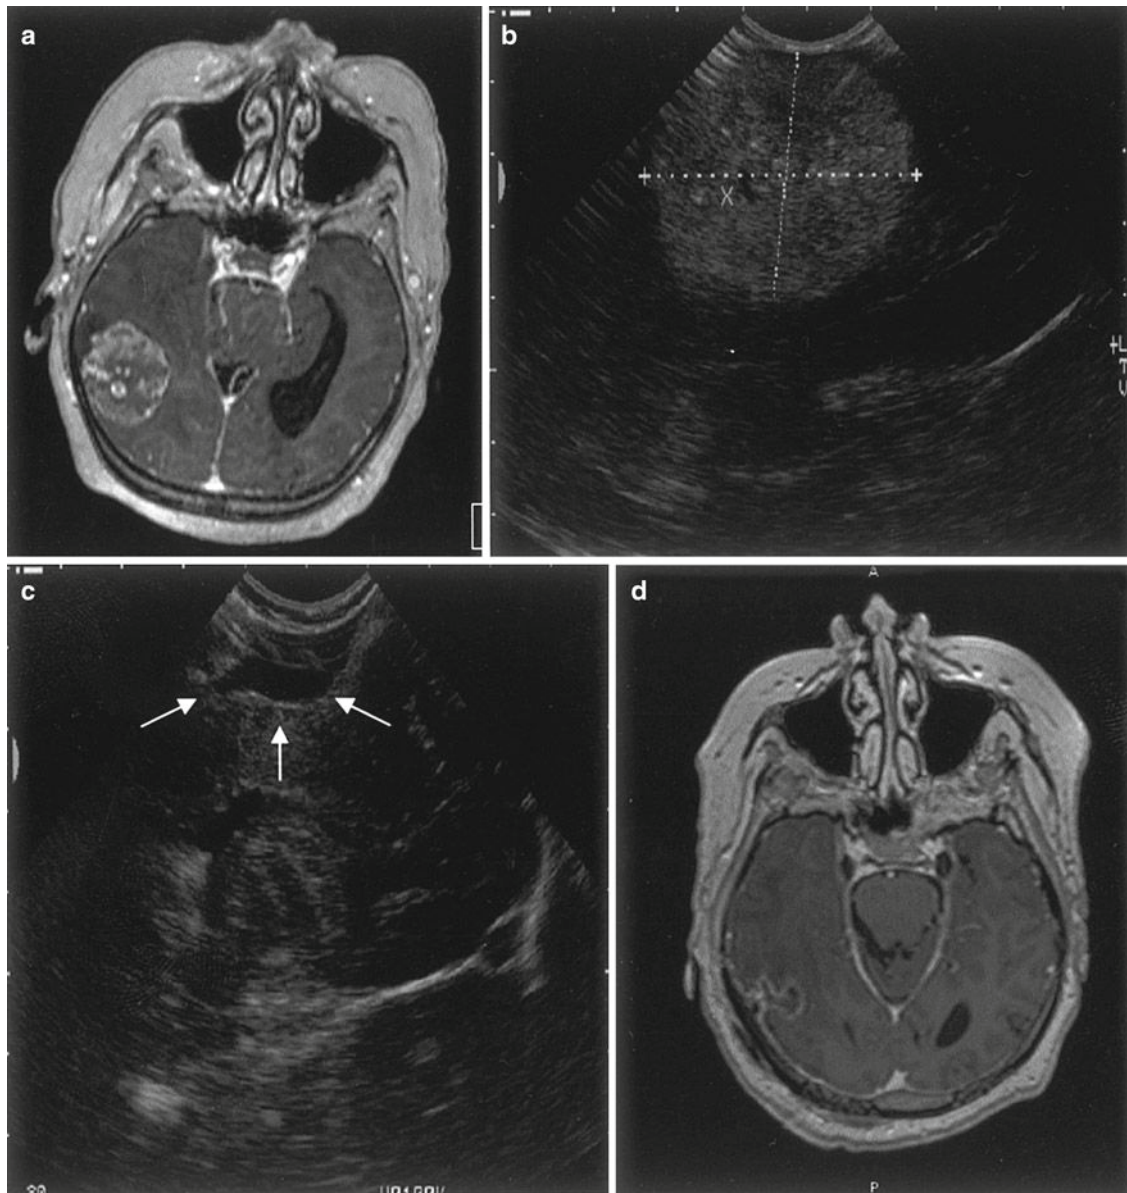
The sequence of images represents the good result of intra-operative ultrasound guided surgery in case of a right temporal metastasis. (a) Preoperative MRI with contrast medium; (b) intra-operative ultrasound before resection with the well defined tumor; (c) resection control after complete tumor removal, the arrows point out the rim of the resection cavity; (d) postoperative MRI with contrast medium showing no residual tumor masses
